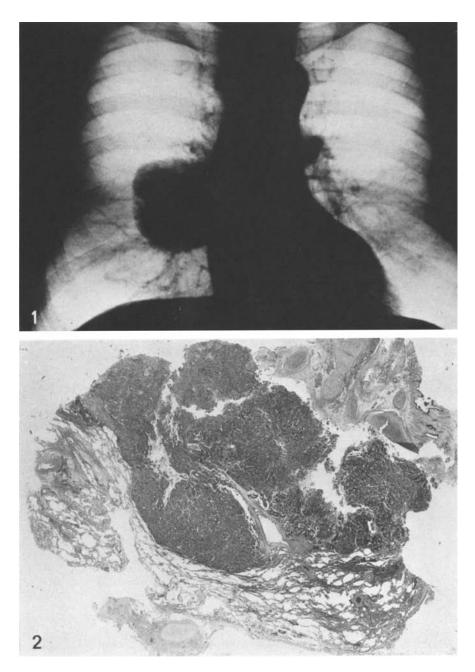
Chest roentgenogram with an almost circular tumour shadow near to the hilus within the right lower lobe of the lung
